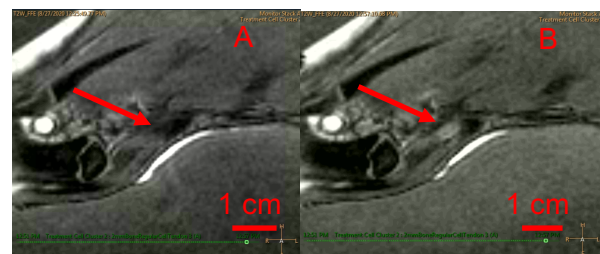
T2-weighted images for treatment of Achilles tendon (arrow) at 40W in the transverse plane. The pre-sonication image (A) and post-sonication image (B) show the change in area of hyperintensity (arrow), which corresponds to edema and successful delivery of FUS ablation onto the tendon.
